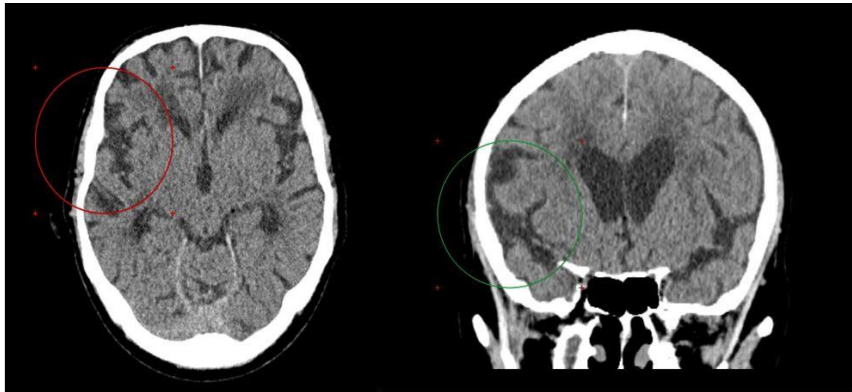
CT scan shows dilated sylvian fissure in axial and coronal sequences, from left to right respectively.
